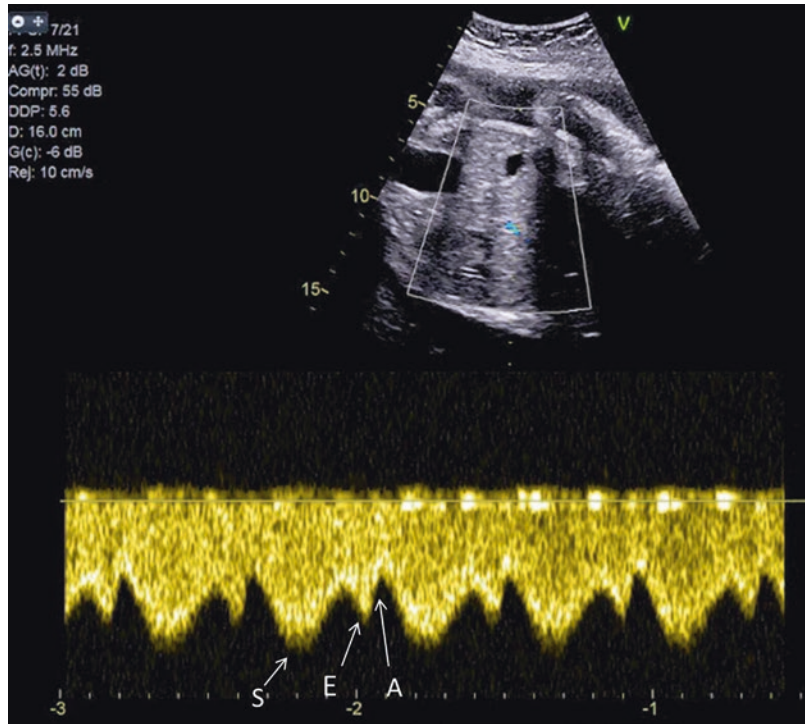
Doppler flow pattern in normal ductus venosus
